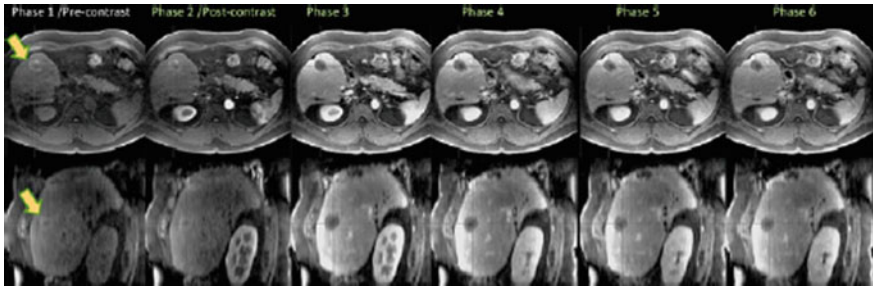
Contrast-enhanced (CE) MRI. Tissue perfusion can be performed using repeatedly a 3D fat-suppressed T_1 -weighted GRE technique after the injection of Gd-DTPA as the enhancement medium. The panels demonstrate both the original axial and the reformatted sagittal views from the MRI perfusion study (phase 1, pre-contrast, phase 2–6 post-contrast) of a patient that had an intrahepatic cholangiocarcinoma (*arrows*) successfully removed with an RF ablation procedure. Acquisition performed at 1.5 T with breath-hold acquisitions of 15 s over a 2 min period and an 8-channel torso coil
